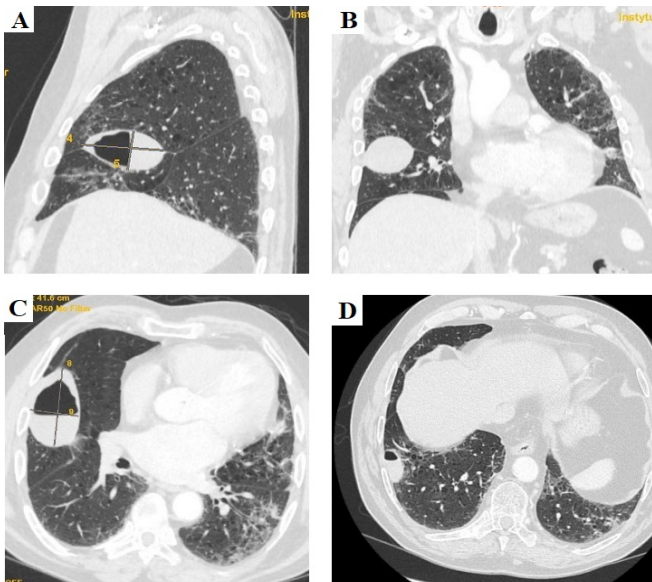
A– A sagittal B– coronal and C– axial CT scan presenting a large cyst in the right lung and D– small pneumatocele in the right lung.
